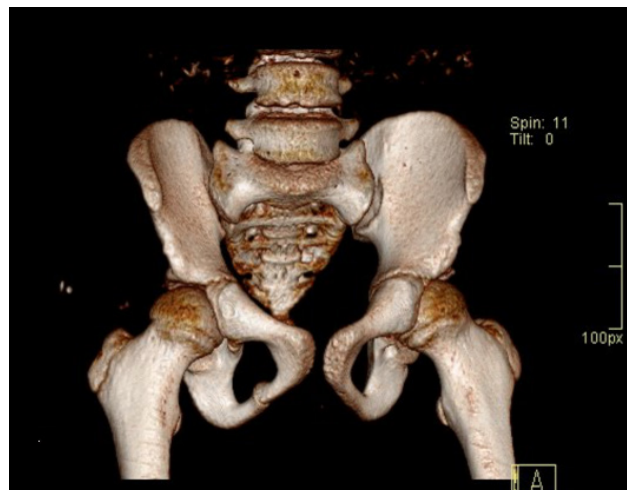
Post op CT scan after 1 year shows no recurrence.
